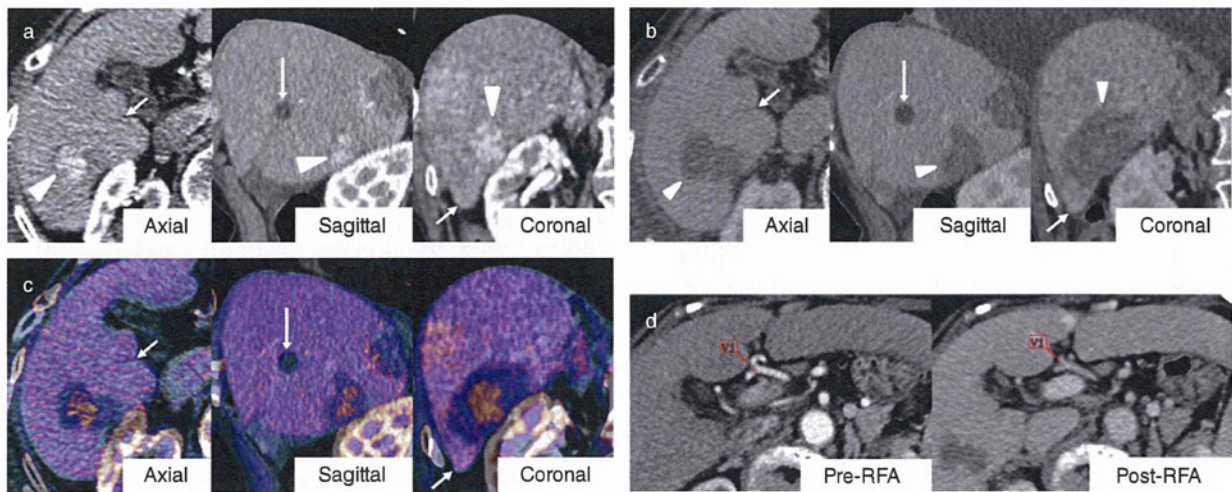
Creation of fusion images of pre-radiofrequency ablation (RFA) and post-RFA computed tomography (CT). (a) Hyper-vascular hepatocellular carcinoma (HCC) in segment 6 (arrowhead) was recognized on pre-RFA dynamic CT (arterial phase). (b) Ablation zone (arrowhead) was hypoattenuated on post-RFA dynamic CT (portal phase). (c) After automatic rigid registration, manual adjustment was added referring to intrahepatic structures such as cyst (long arrow) and hepatic contours (short arrow) around the tumor using six parameters (translation and rotation in axial, sagittal and coronal planes). For better discrimination of pre-RFA and post-RFA CT image, they were shown in color scale and gray scale, respectively. (d) After registration, one arbitrary landmark near the tumor was marked both on the pre-RFA and post-RFA CT and the registration error was measured. The registration error of this case was 1.48 mm. The slice thickness of both pre-RFA and post-RFA CT was 1.25 mm in this case.
